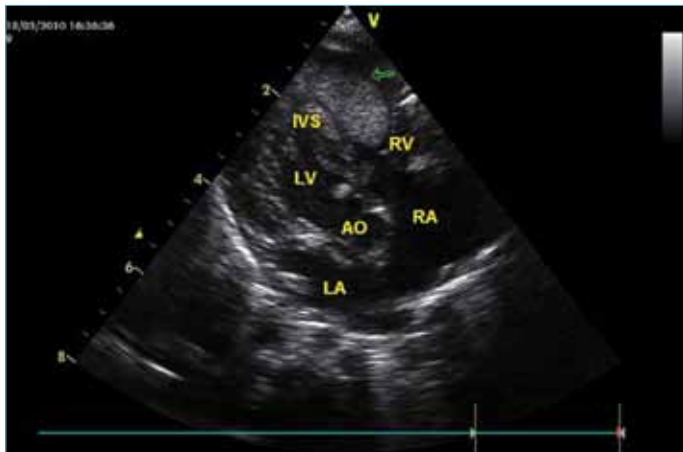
Echocardiographic image of case number 6
